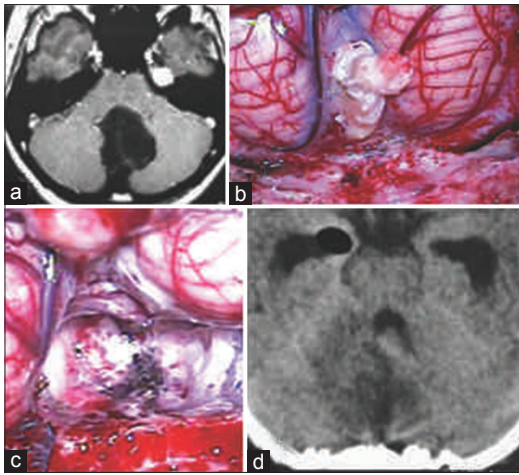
(a) Axial T1-weighted MRI image revealing hypointense lesion located in the cerebellar vermis with invasion of the 4th ventricle. (b) Operative view showing the tumor, with numerous hair follicles, protruding from the cerebellar vermis in the cistern magna. (c) Operative image showing GTR. (d) Immediate postoperative CT confirming the GTR
